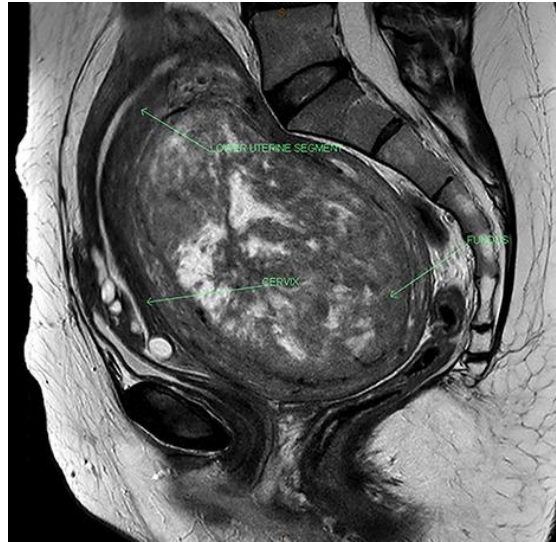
Magnetic resonance imaging of the leiomyosarcoma
